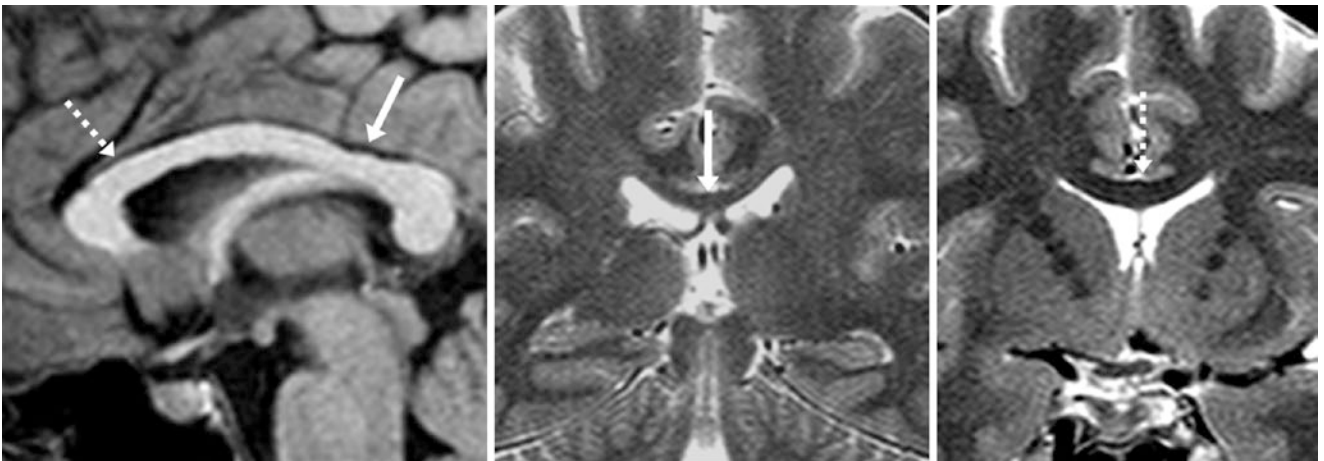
A 31 year old with an otherwise negative MRI obtained for headaches, which showed a normal callosal isthmus on a midline sagittal T1WI (arrow, left). Coronal T2WIs through the callosal isthmus
